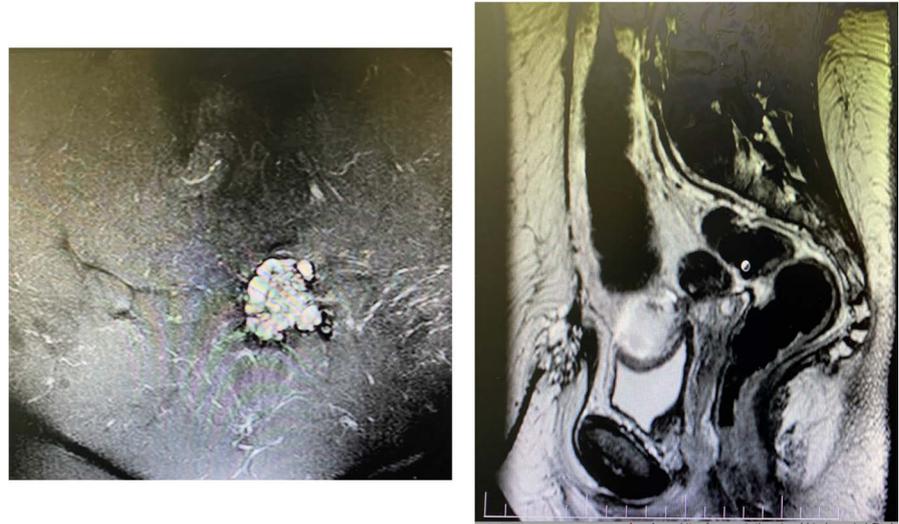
MRI images showing anterior abdominal wall cystic lesion.
